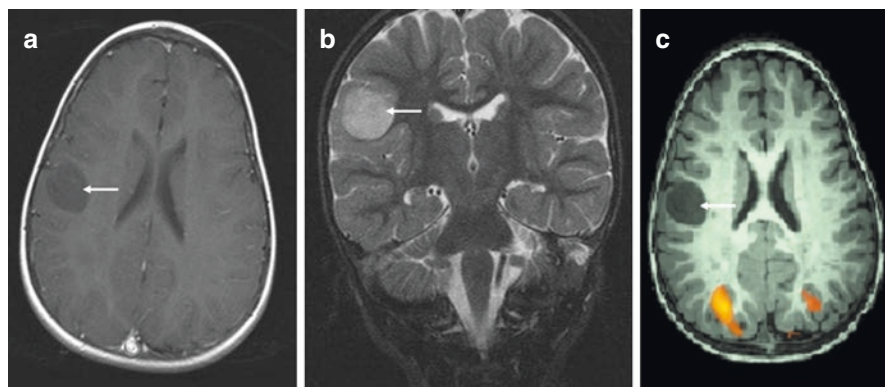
MR images of a patient with C19MC-altered ETMR including (a) T1-weighted axial MRI brain with contrast, (b) T2-weighted coronal MRI brain, and (c) T1-weighted axial functional MRI brain. Images display a well-circumscribed lesion in the inferior right precentral gyrus, involving the cortex and subcortical region (a–c arrow). Hypointensity on T1-weighted images and hyperintensity on T2-weighted images are seen (a–c). Subtle restricted water diffusion is seen with no significant enhancement (c)
